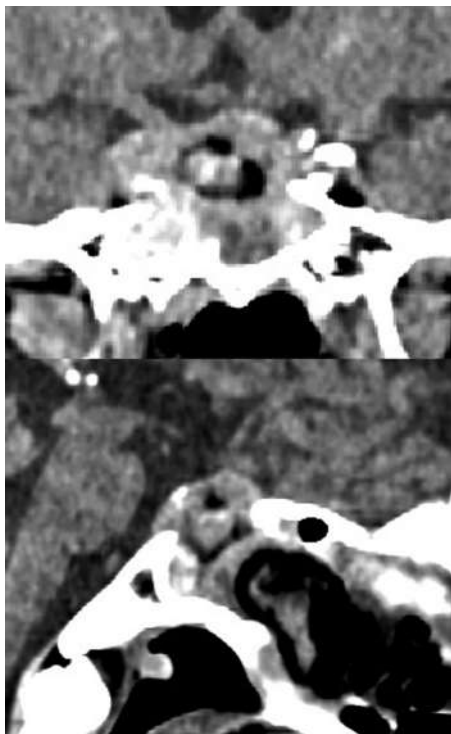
Immediate postoperative CT scan with hemostatic material inside the sella and significant tumor reduction.
